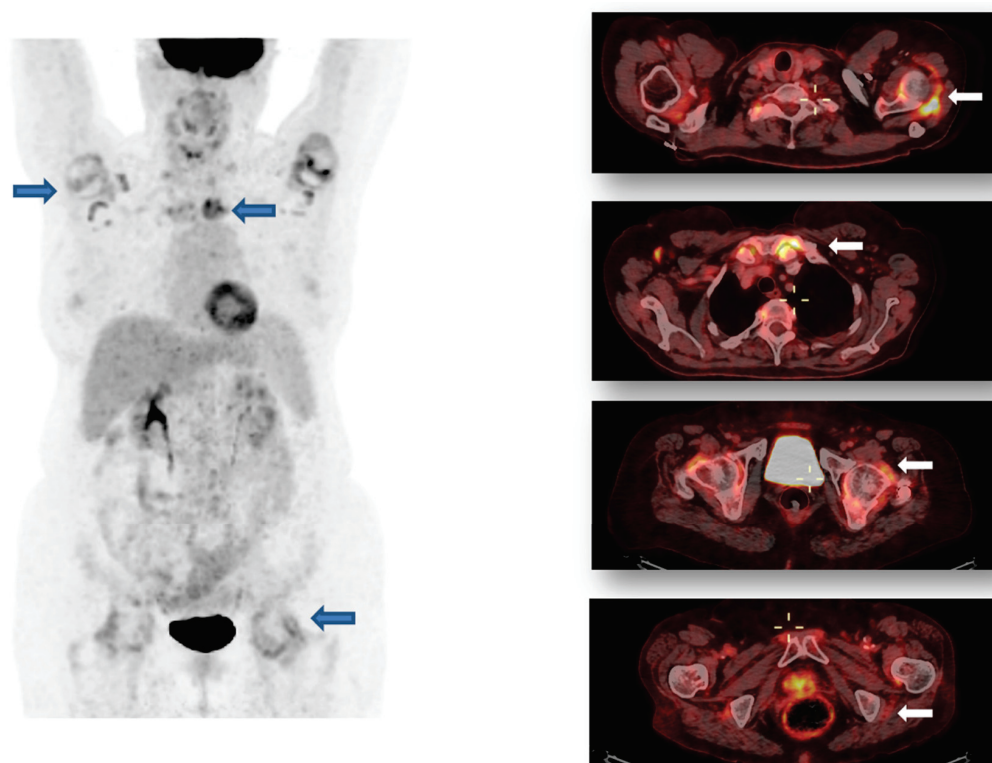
82 year old woman with significant FDG uptake around the glenohumeral, sternoclavicular, costovertebral joints, lumbar interapophyseal spaces, coxofemoral joints, ischial tuberosities, and pubis, suggestive of diffuse osteoarticular pathology with an inflammatory component, in the context associated with PMR. Blue arrows: FDG uptake around glenohumeral, sternoclavicular and coxofemoral joint. White arrows: FDG uptake around glenohumeral, sternoclavicular, coxofemoral and ischial tuberosities.
